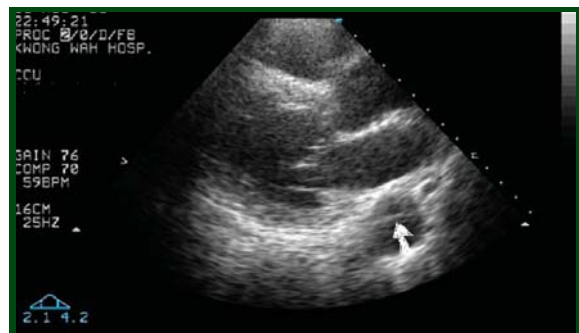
Dissection flap in descending aorta from parasternal long axis view
